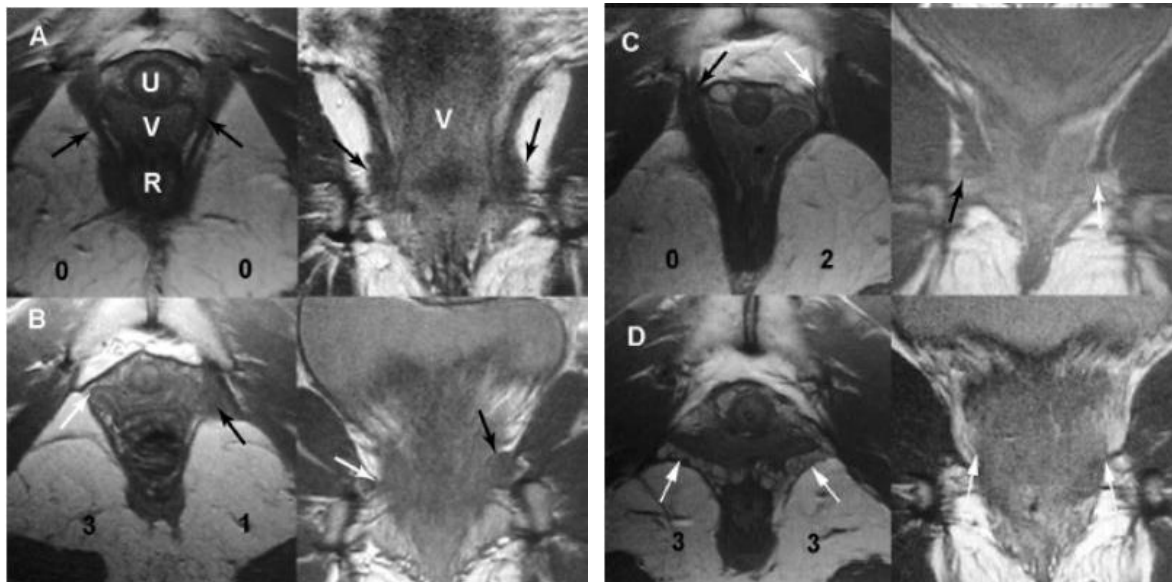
On axial and coronal magnetic resonance images, these examples show the different levels of damage to the levator ani pubovisceral muscle. A: A woman whose muscles are normal; B and D: Three women who each have a major disability; and C: Three women who each have a minor disability. The scores for each side are shown by the handicap scores on the left. There are black arrows that show where the muscle should be and white arrows that show where the muscle is damaged or should be. U stands for the urethra, V for the vaginal canal, and R for the rectum.<sup>2</sup>
